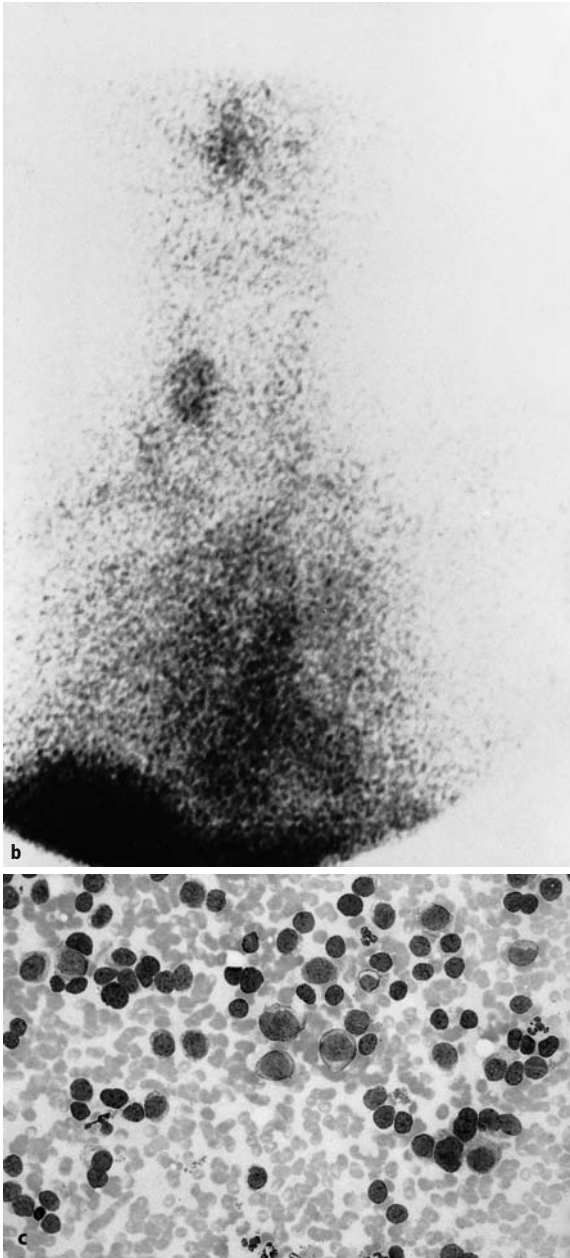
b-c b Immunoscintigraphy with a ^{99m}Tc -labeled anti-CEA antibody, clone BW431/26, shows intense antibody accumulation in this nodule in the right lobe of the thyroid. c Fine-needle aspiration cytology
